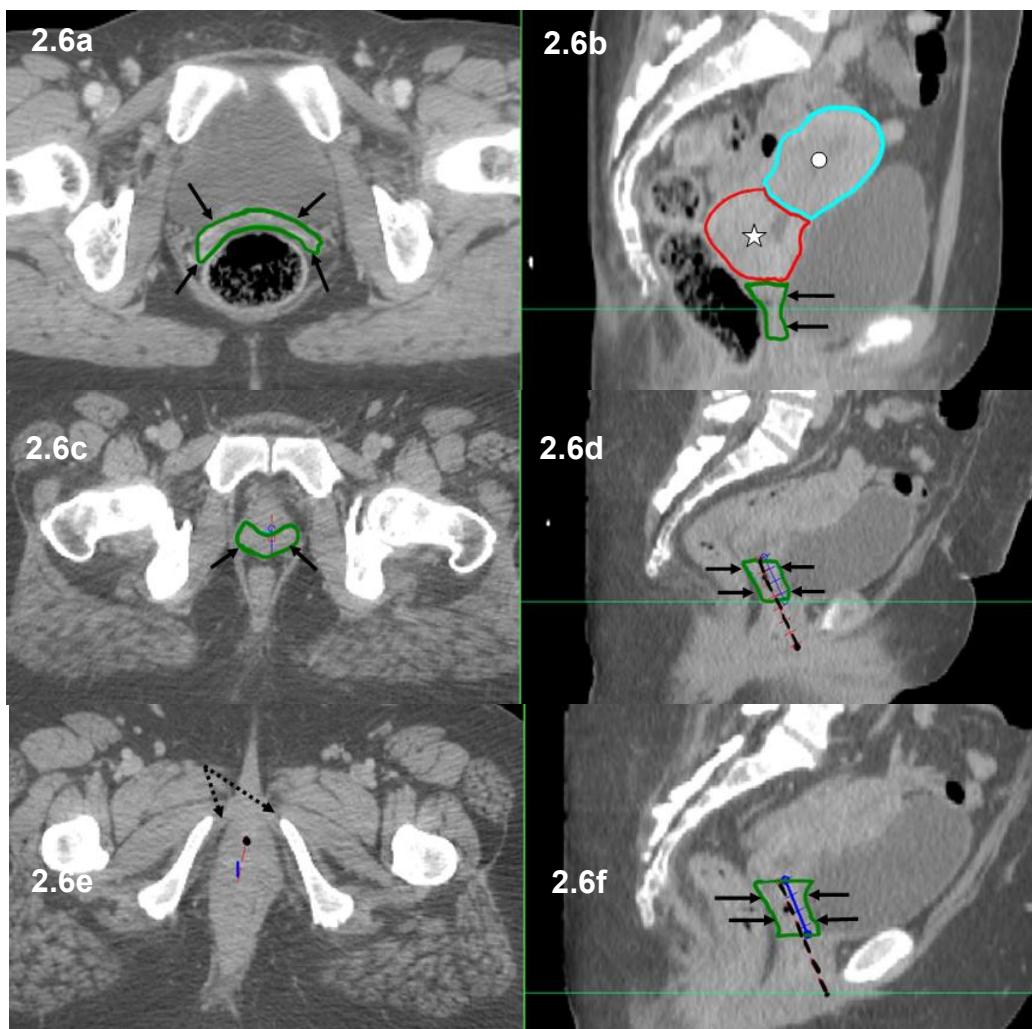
Axial (a,c,e) and sagittal (b,d,f) CT showing upper half of vagina (green), uterus (circle) and cervix (star); dashed line follows length of vagina; arrow on e shows clitoral crura at ~ inferior axial slice of vagina
